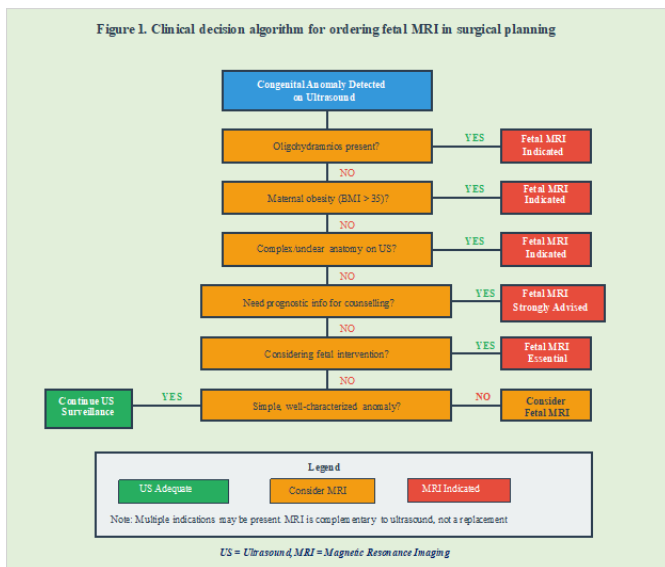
Clinical decision algorithm for ordering fetal MRI in surgical planning.
